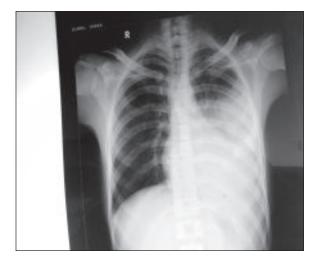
X-ray: Left sided pleural effusion (Before treatment) Source: Personal collection from my consultation chamber
